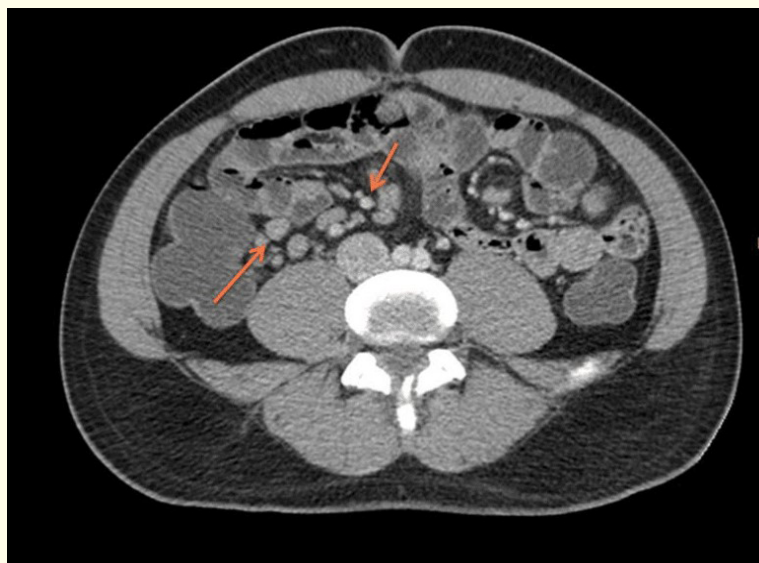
Contrast tomographic study of the abdomen with the presence of adenopathies up to 1cm in the entire mesentery, mild splenomegaly. Computed tomography demonstrating multiple adenopathies in the mesentery. Image courtesy of the Image Service of the Metropolitan Hospital.
